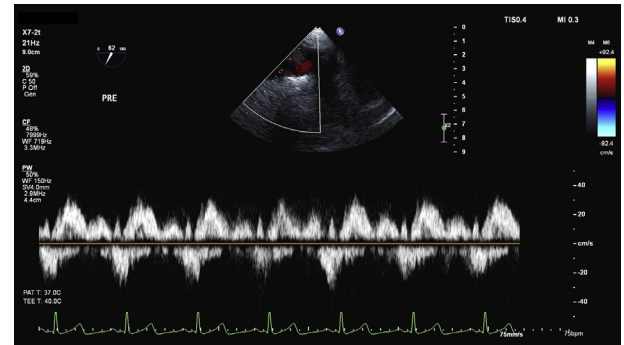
Pulsed-wave Doppler of the hepatic vein showing normal Doppler flow.
